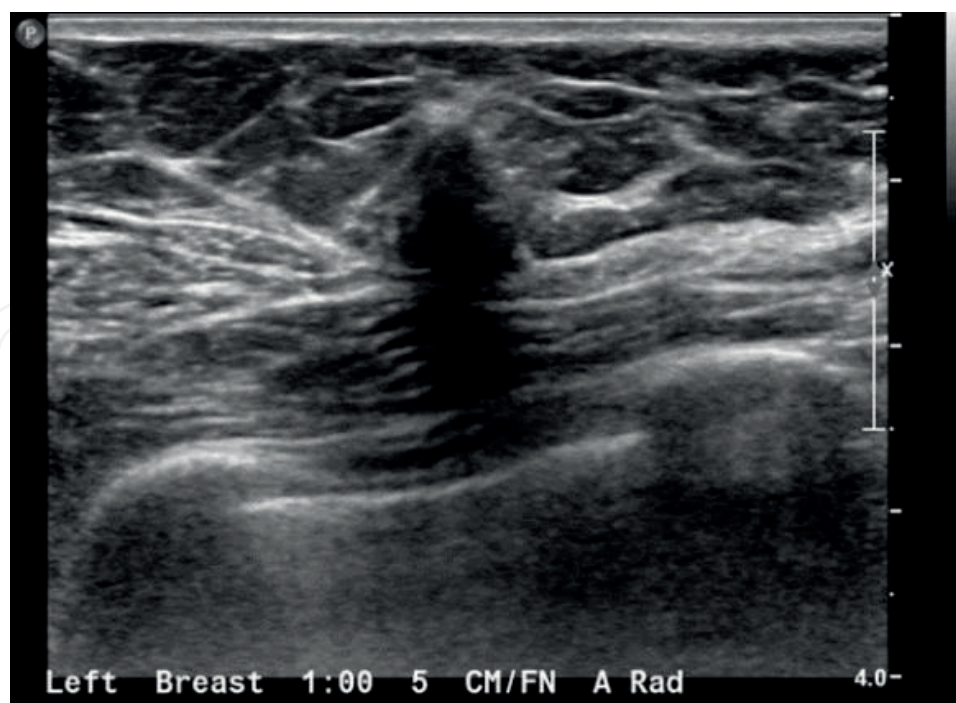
Transverse ultrasound of the left breast demonstrates an irregular, antiparallel mass with posterior acoustic shadowing.
